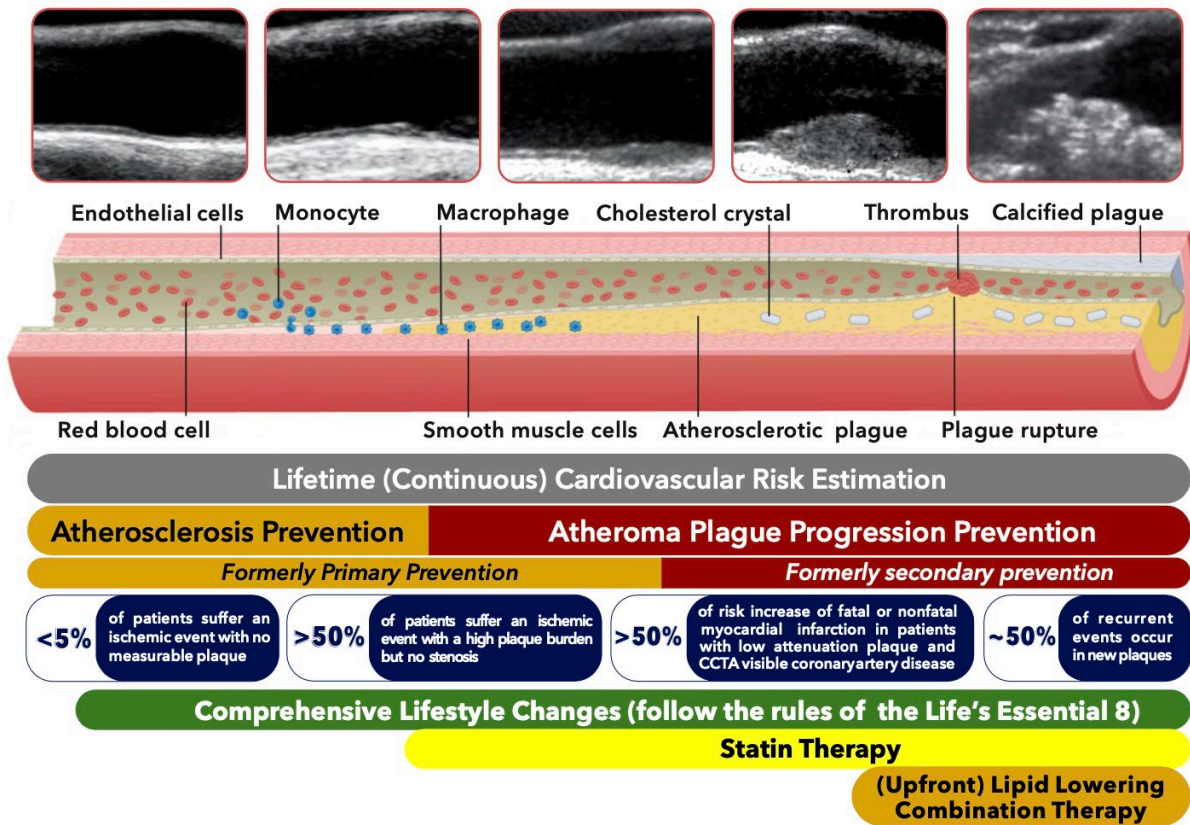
The practical guidance on risk stratification and management of patients at different stages on atherosclerosis process. Modified and redrawn based on Raitakari *et al.* [62] with permission (No.: 5834370924715) and Blaha *et al.* [63] (no permission required). Abbreviations: CCTA - Coronary Computed Tomography Angiography.
